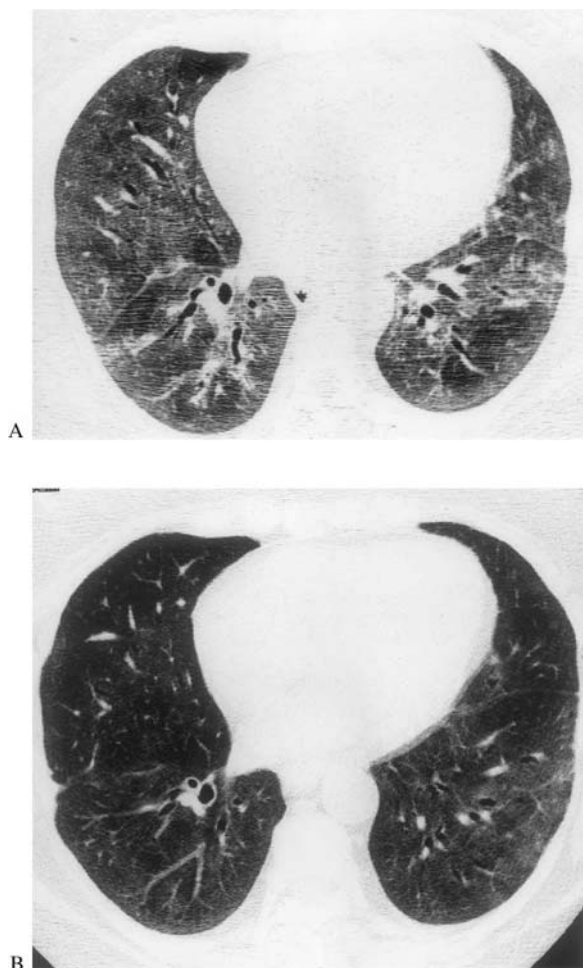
(a) Dermatomyositis. HRCT demonstrates diffuse ground-glass attenuation in a patient with DM, dyspnea, and a restrictive ventilatory defect. (b) HRCT from the same patient 3 weeks after institution of high dose corticosteroid therapy showing marked improvement. (Reproduced with permission from Lynch et al., 1999.)
